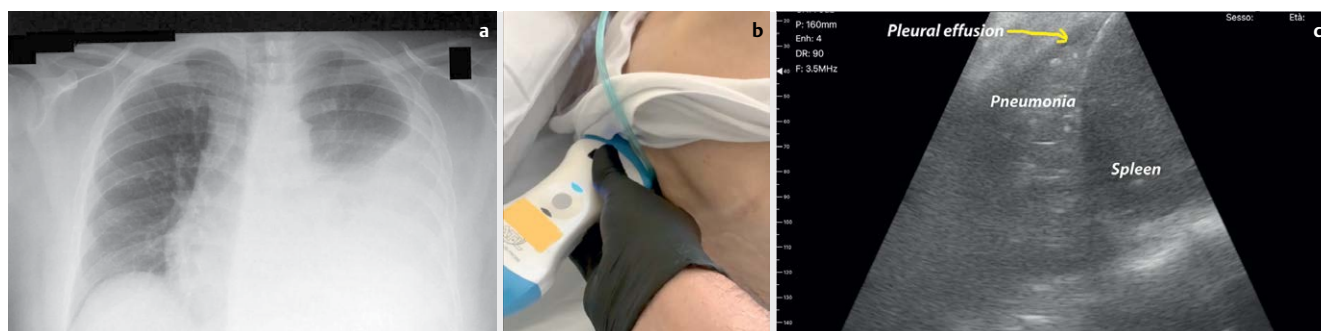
A case of etiological diagnosis: female, 89 years old; resident of a retirement home; patient affected by senile dementia and therefore non-cooperative; she comes to the emergency room with dyspnea and fever; on X-ray left pleural effusion (a), but without signs of pneumonia; after hospitalization in the internal medicine department, pulmonary objectivity is not possible due to the clinical conditions and the poor compliance of the patient (b); on MED MED-US large basal pneumonia (c).
